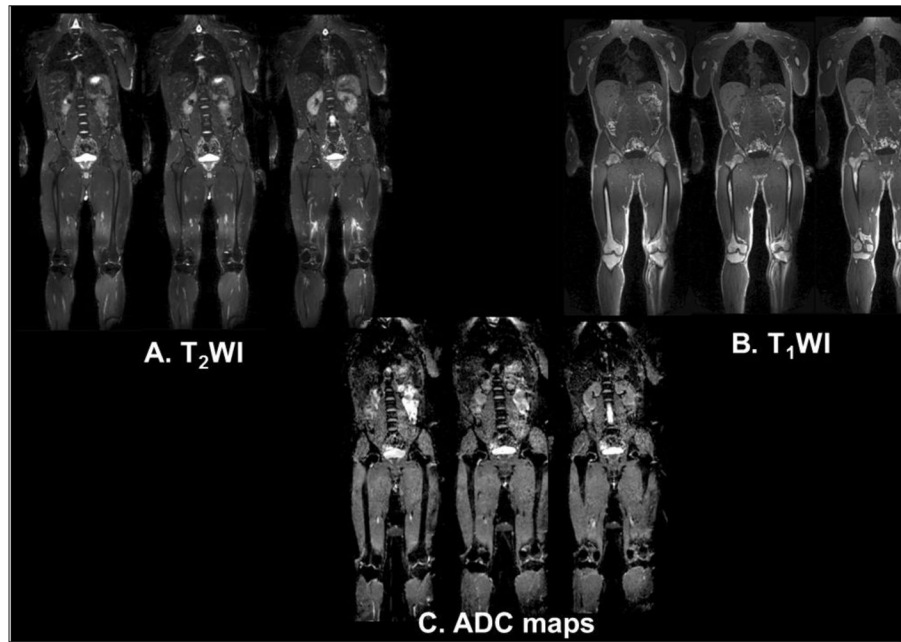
Demonstration of multiparametric whole-body MRI in a normal subject. A. T2-weighted imaging through the central slices in the body. B. T1-weighted images and C. ADC maps of the same location in the normal subject.
